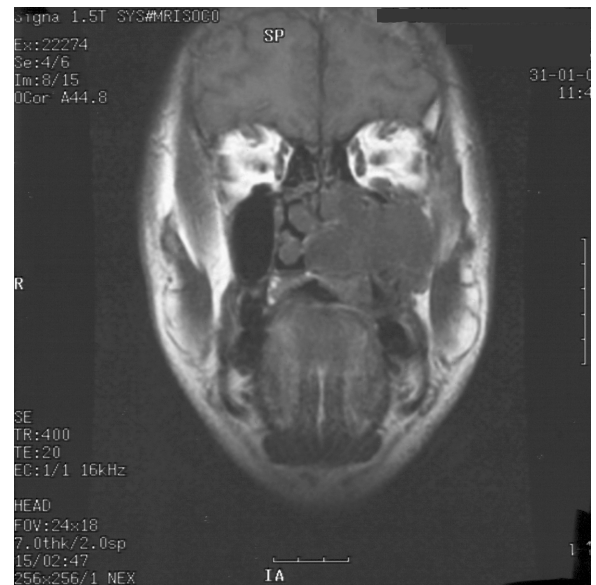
Same patient as in Figs 5 and 6. Coronal T1 MRI without contrast of ACC filling the left nasal cavity and left maxillary sinus with extension and loss of fat in the left infratemporal fossa. Perineural tumour spread again noted along V2 in the infraorbital foramen.
